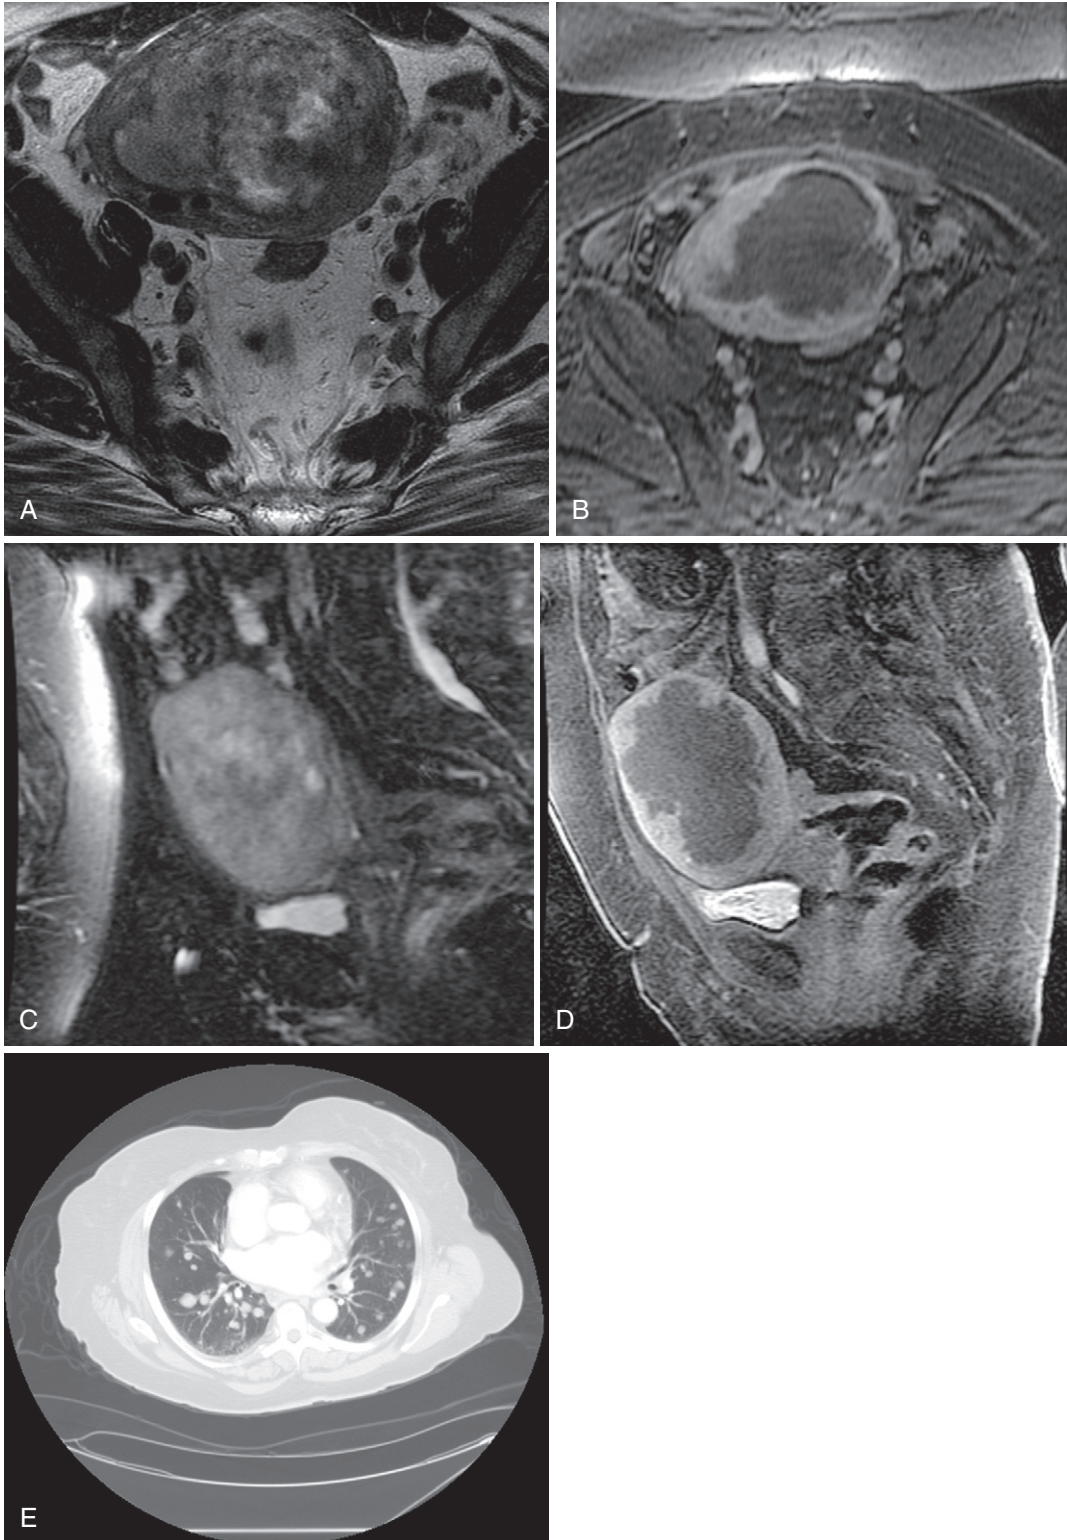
Leiomyosarcoma. Axial T2-weighted (A) and enhanced (B) and sagittal T2-weighted fat-suppressed (C) and enhanced (D) images show a large, necrotic, poorly defined mass essentially replacing the entire uterine corpus and associated with lung metastases on the corresponding computed tomography (CT) scan (E).
